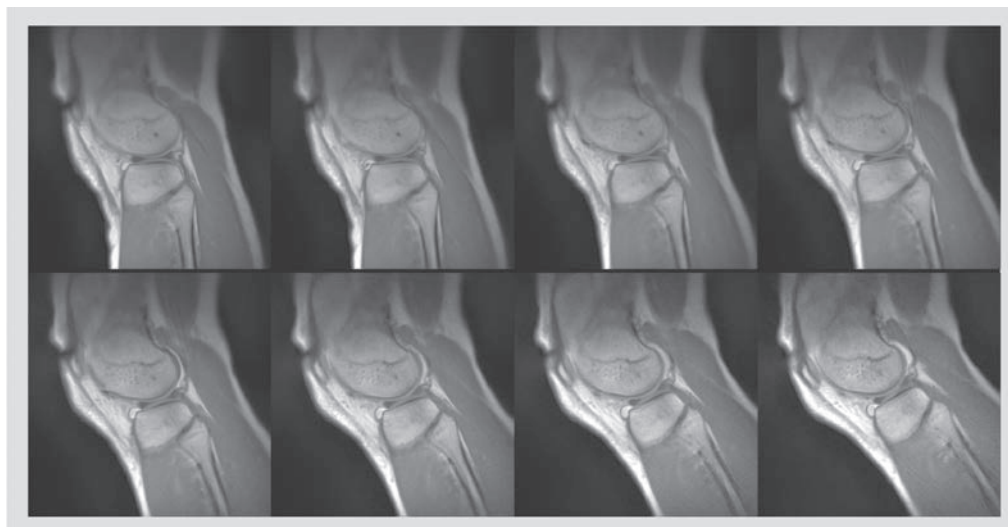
Real-time MRI of voluntary knee bending after a mild contusion. Selected frames taken every 4 s from (top and bottom) two different sections of respective movies at 333 ms temporal resolution (3 fps) acquired using refocused radial fast low-angle shot (73 spokes, repetition time/echo time = 4.56/2.30 s, flip angle 25°, $0.75 \times 0.75 \times 5.0 \text{ mm}^3$).
